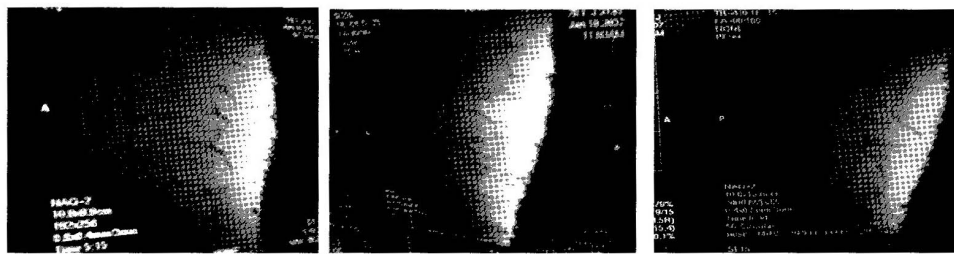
Sagittal plane T1-weighted pre-treatment images of patients 1, 2 and 3.
